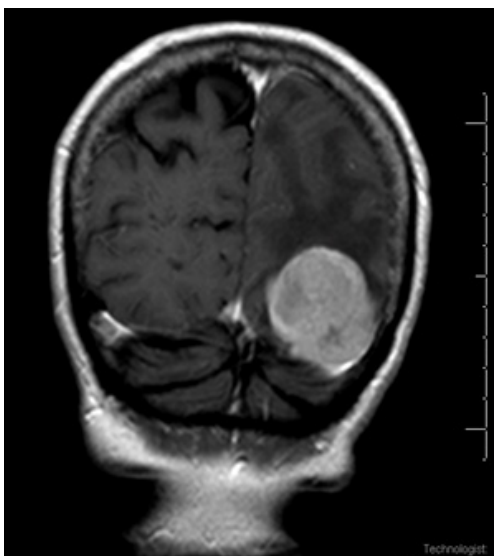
MRI post contrast T1 gadolinium image. Coronal view: 4.4 cm × 3.6 cm × 4.5 cm well-circumscribed heterogeneously enhancing soft tissue mass in the paramedian aspect of the left occipital lobe with surrounding vasogenic edema.
